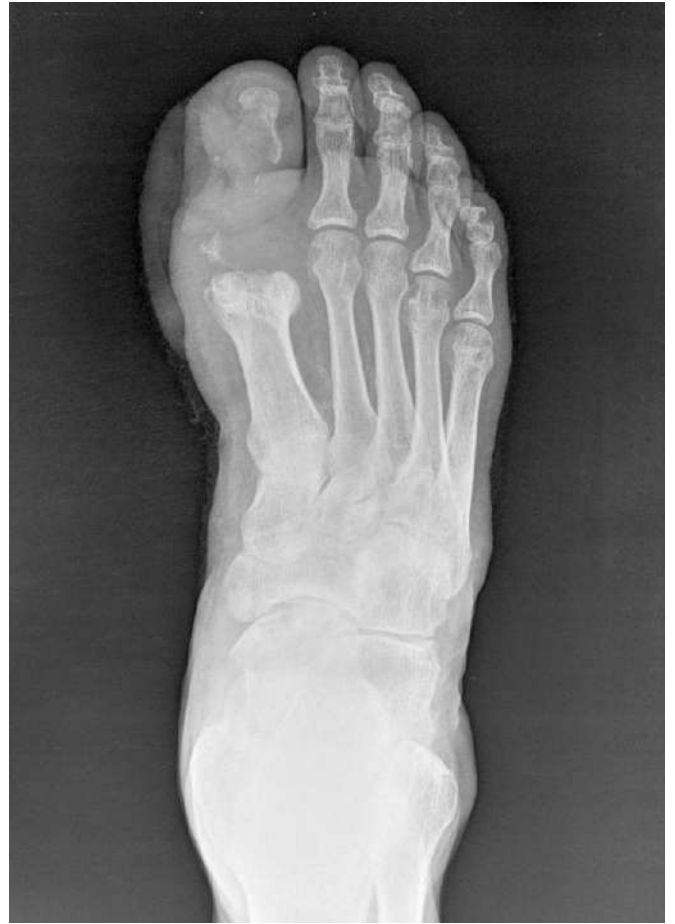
Radiograph of the treated foot on the 1st post-operative day.
